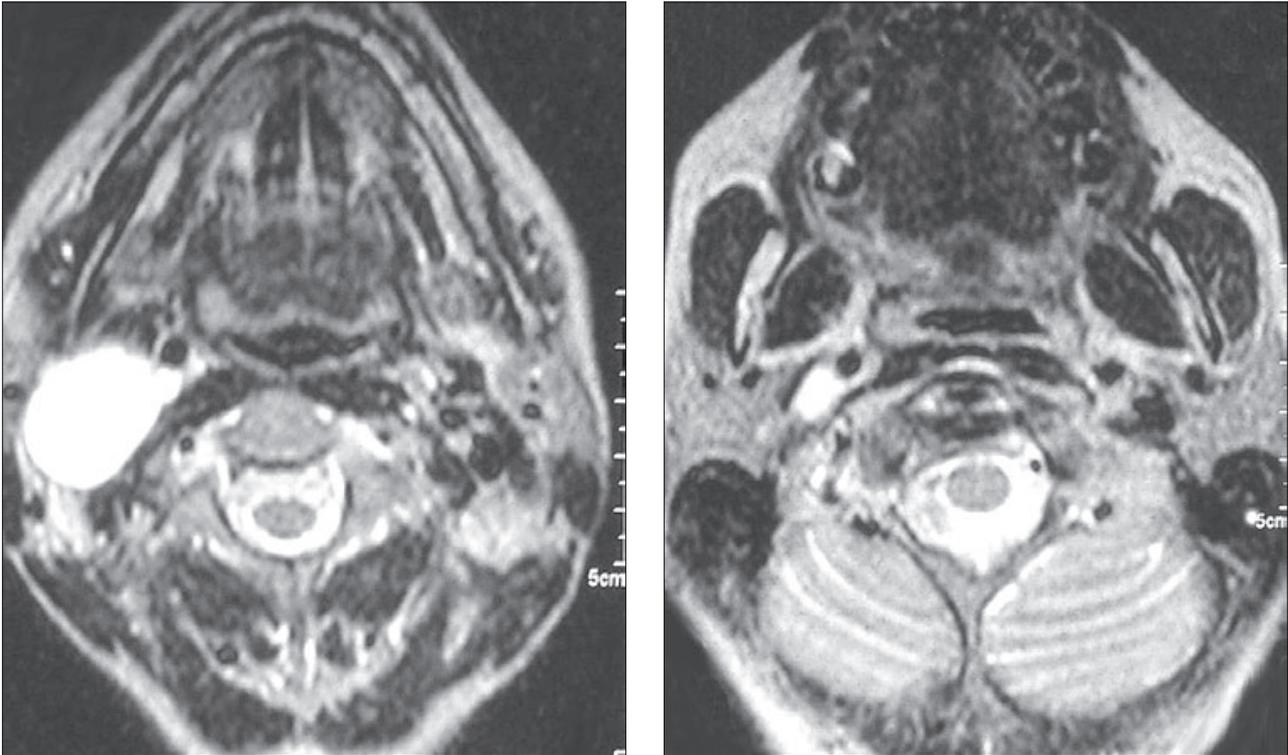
MR axial T1 and T2 weighted MRI scan.
